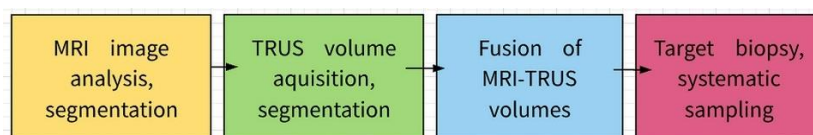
Steps in software MRI-fusion biopsy.
